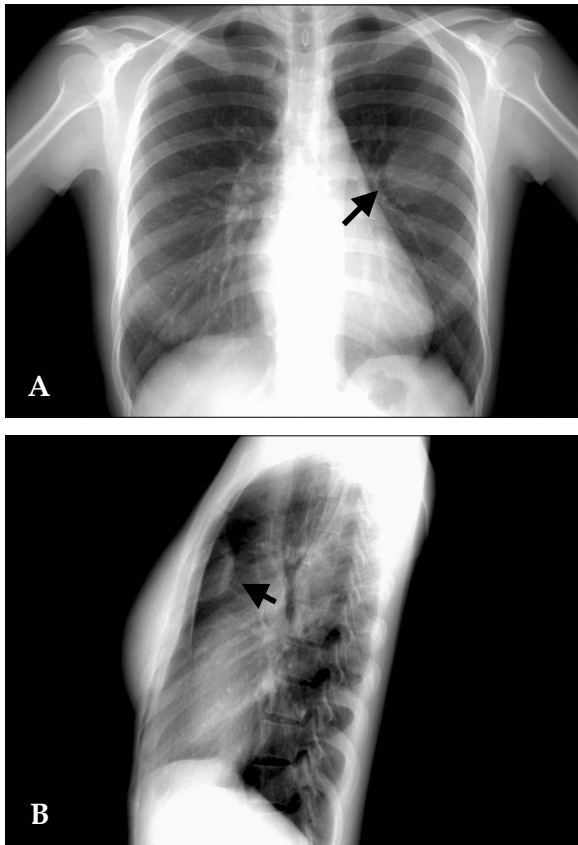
The posteroanterior (A) and lateral (B) chest radiograph revealed a round mass lesion (arrows) in the left anterior chest.
